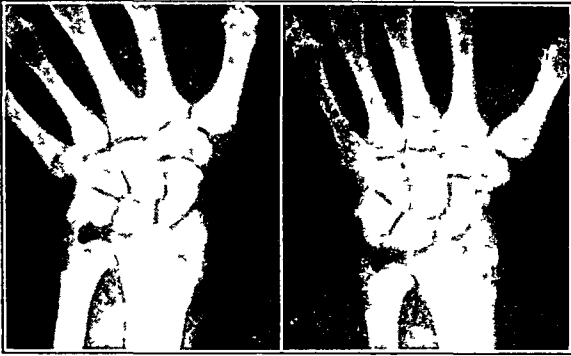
A striking photograph to bring out the rigid rule in technic that the hand must be in sharp ulnar deviation when roentgenograms are taken of the wrist. On the right, the normal anteroposterior view shows no evidence of fracture. On the left, same case, with the hand in sharp ulnar deviation a typical well marked fracture of the middle third of the scaphoid is brought out.
